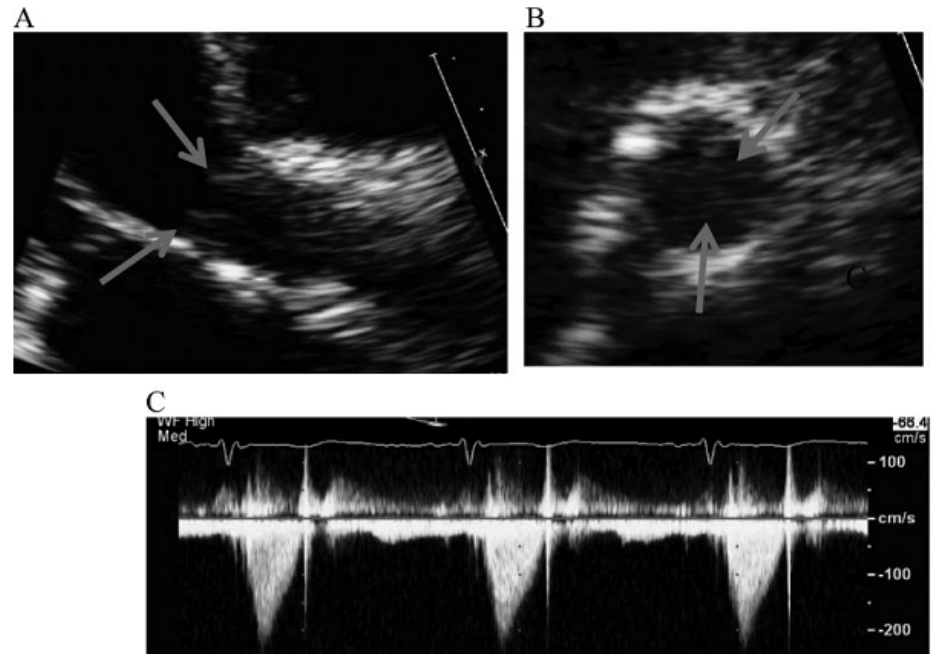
Echocardiography images after 1 month of anticoagulant therapy shows thinner leaflets of the Sapien valve (long-axis view [A] and short-axis view [B]) and a reduction of transvalvular gradient (C).
